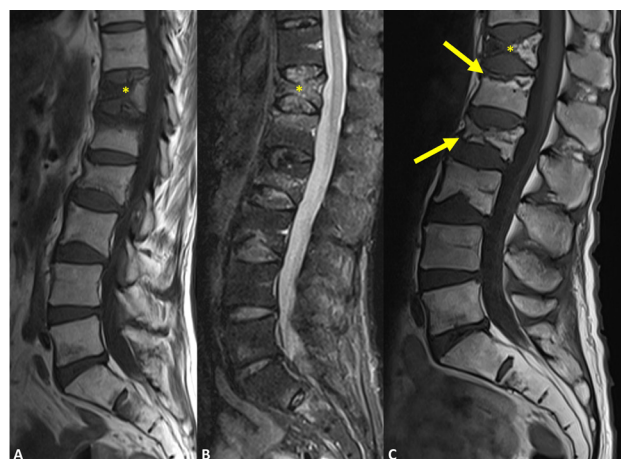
Sagittal T1-weighted (A) MRI images acquired one month after symptom onset, demonstrate further collapse of the T12 body (yellow asterisk), with well-defined T1 low signal and bone marrow oedema localised to T12 body and the adjacent L1 endplate, without involvement of the posterior elements or an associated soft-tissue mass. These findings are consistent with progression of T12 collapse and impending L1 fracture. Sagittal STIR (B) demonstrates faint bone marrow oedema in the L2, L3, and L5 vertebral bodies. Sagittal T1-weighted MRI image (C) acquired one year after symptom onset shows increased collapse of the T12 (yellow asterisk), L2, and L3 vertebral bodies and development of fracture lines in L2 and the upper endplate of L1 (yellow arrows).
